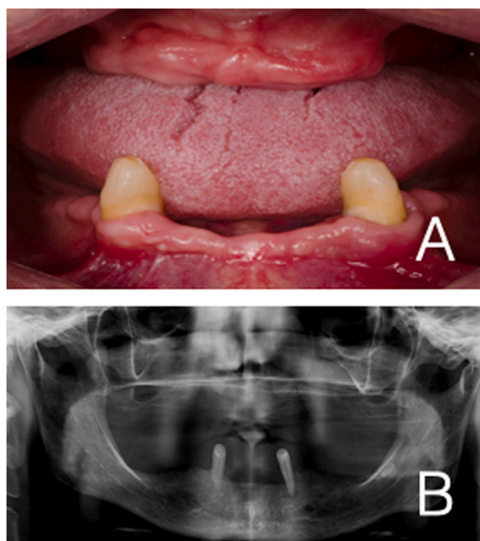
Preoperative clinical (A) and radiographic (B) images of a typical case satisfying the inclusion criteria: fully edentulous upper maxilla that cannot be treated with conventional implants, and where bone grafting, Le Fort I osteotomy, and distraction osteogenesis procedures are ruled out.
